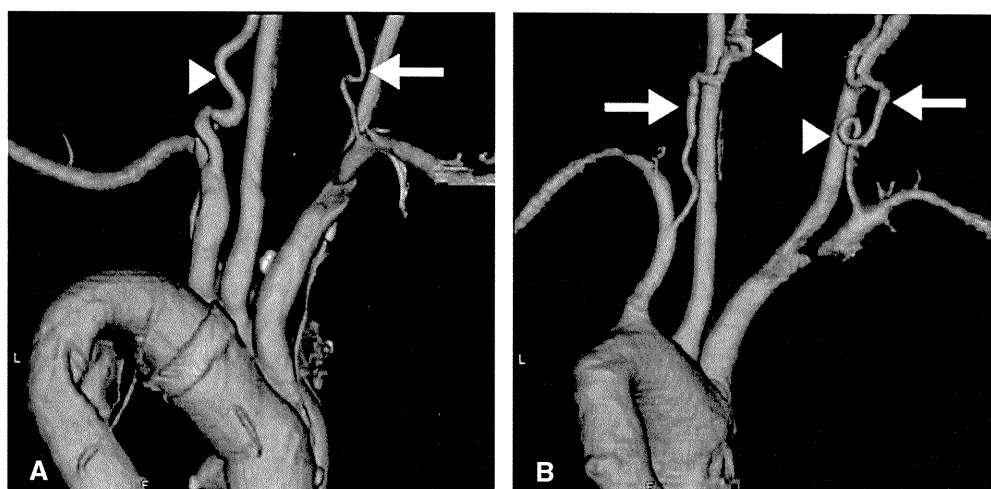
a Computed tomography angiography (CTA) image, posterior view, of a 37-year-old patient with Loey-Dietz syndrome (LDS). The patient is in a postoperative stage after aortic dissection. The right vertebral artery (*arrow*) is graded 0, and the left vertebral artery (*arrowhead*) as 1 because of its multiple curves. b CTA image from posterior view of a 19-year-old LDS patient. The
